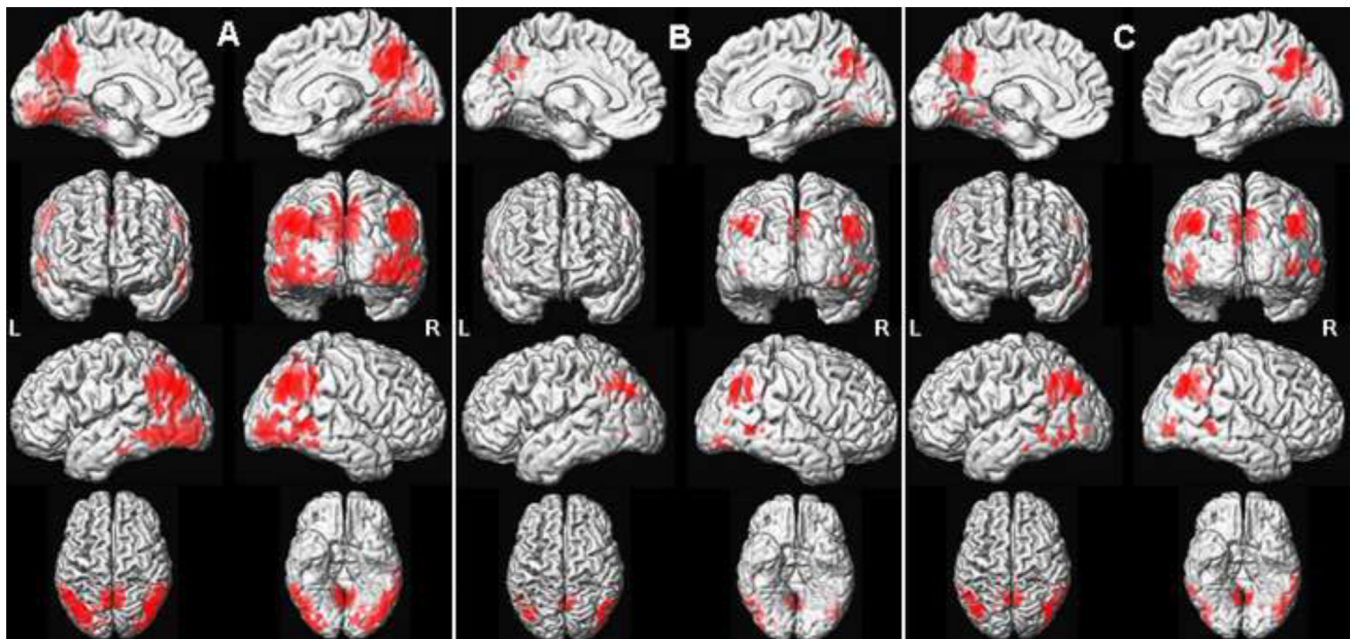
Regional FDG hypometabolism in patients with DLB
